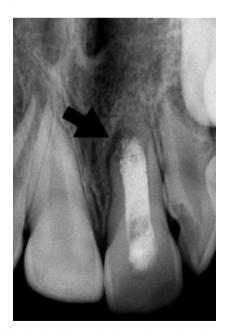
Periapical radiograph taken 18 months after the initial endodontic treatment. Note the presence of an incomplete hard tissue barrier at the end of the root (arrow).
